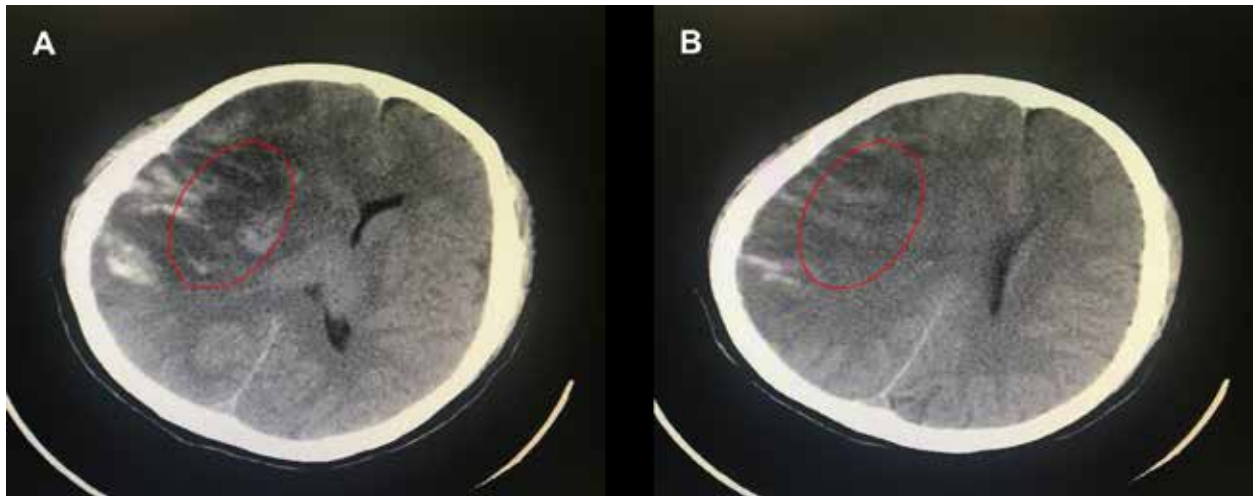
CT images of 60-year-old female with cerebral infarction one day after surgery.
